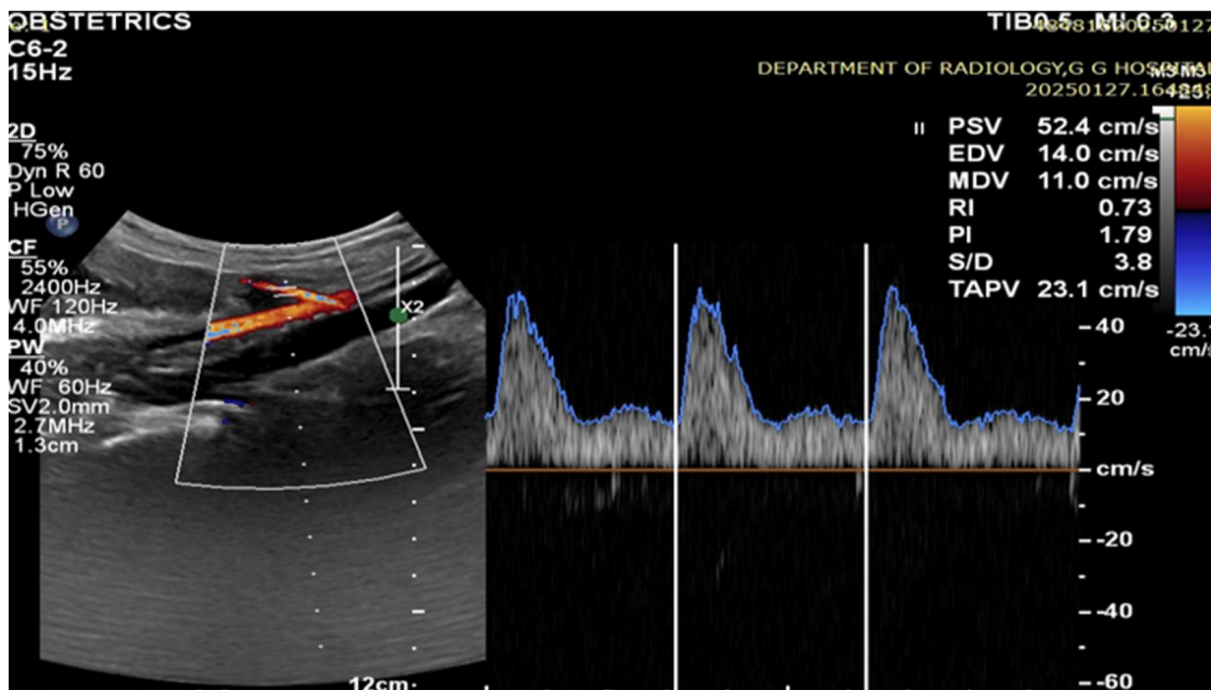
Abnormal uterine artery Doppler with elevated RI and PI and proto-diastolic notch
